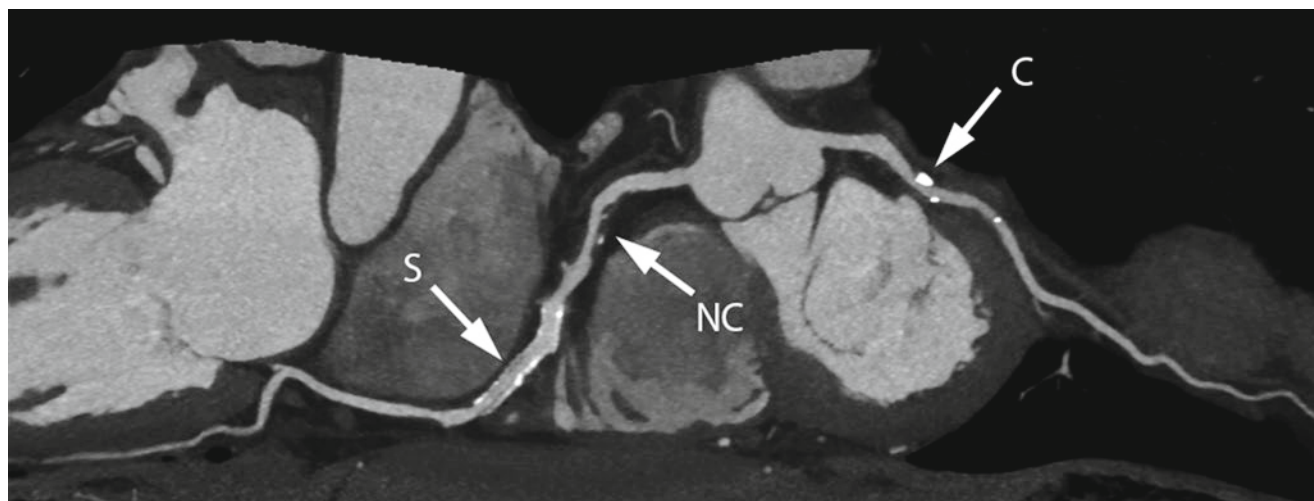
Contemporary contrast-enhanced coronary CT angiography data set, in this case acquired with dual-source CT, 2×192 slice acquisition, 250 ms rotation time, and a temporal resolution of 66 ms. The
